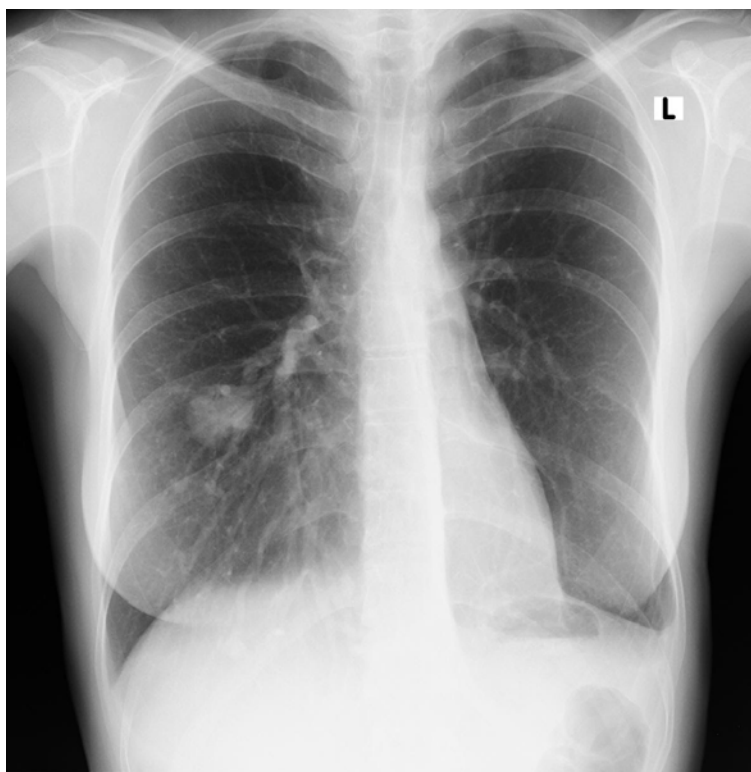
Chest x-ray in standing and posterior anterior (PA) position shows relatively homogeneous, relatively well defined shadow, intensity of the soft tissue, size about 35 mm in the right hemithorax, in the inferior region of the lung on medioclavicular line projection. Also, on the same side, there is voluminous hilus and prominent hila-basal pulmonary vascularity.
